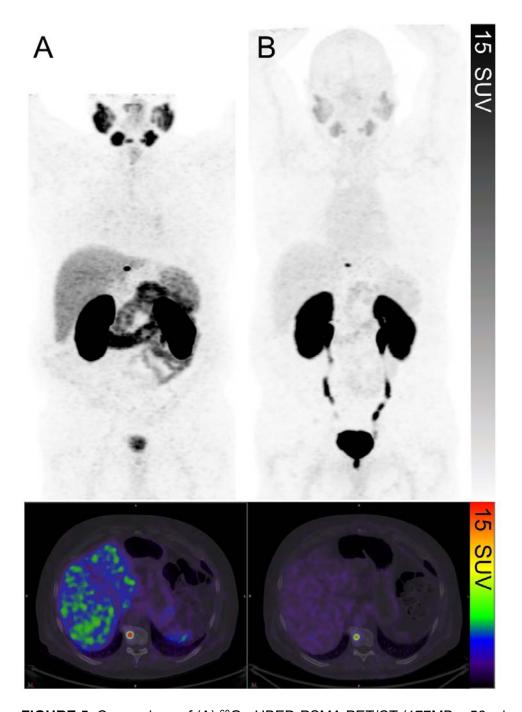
Comparison of (A) ⁶⁸Ga-HBED-PSMA PET/CT (177MBq, 56 minute uptake period) to (B) ⁶⁸Ga-THP-PSMA PET/CT (232 MBq, 60 minute uptake period) in the same patient. Solitary focal intense abnormality in the T10 vertebral body is well-visualised on both. Note the lower background physiologic uptake on the THP-PSMA study.
